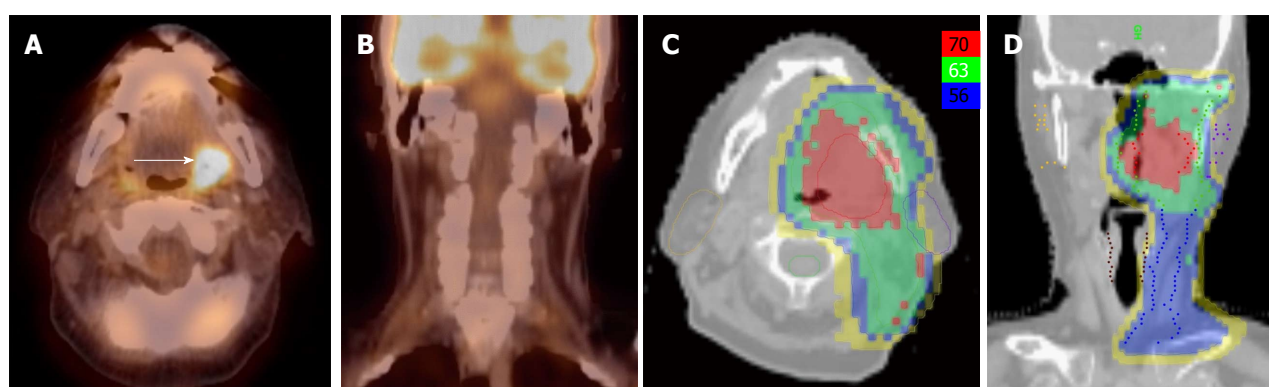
Positron emission tomography/computed tomography allows for unilateral tonsil cancer treatment in a patient with a T2N0 left tonsil cancer. A, B: PET/CT shows no evidence of lymph node metastasis in the contralateral (right) neck; C, D: An IMRT plan of the radiation treatment plan showing effective contralateral sparing. IMRT: Intensity modulated radiation therapy; PET/CT: Positron emission tomography/computed tomography.
